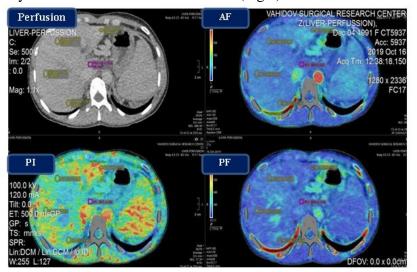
CT perfusion of the liver in extrahepatic portal hypertension
